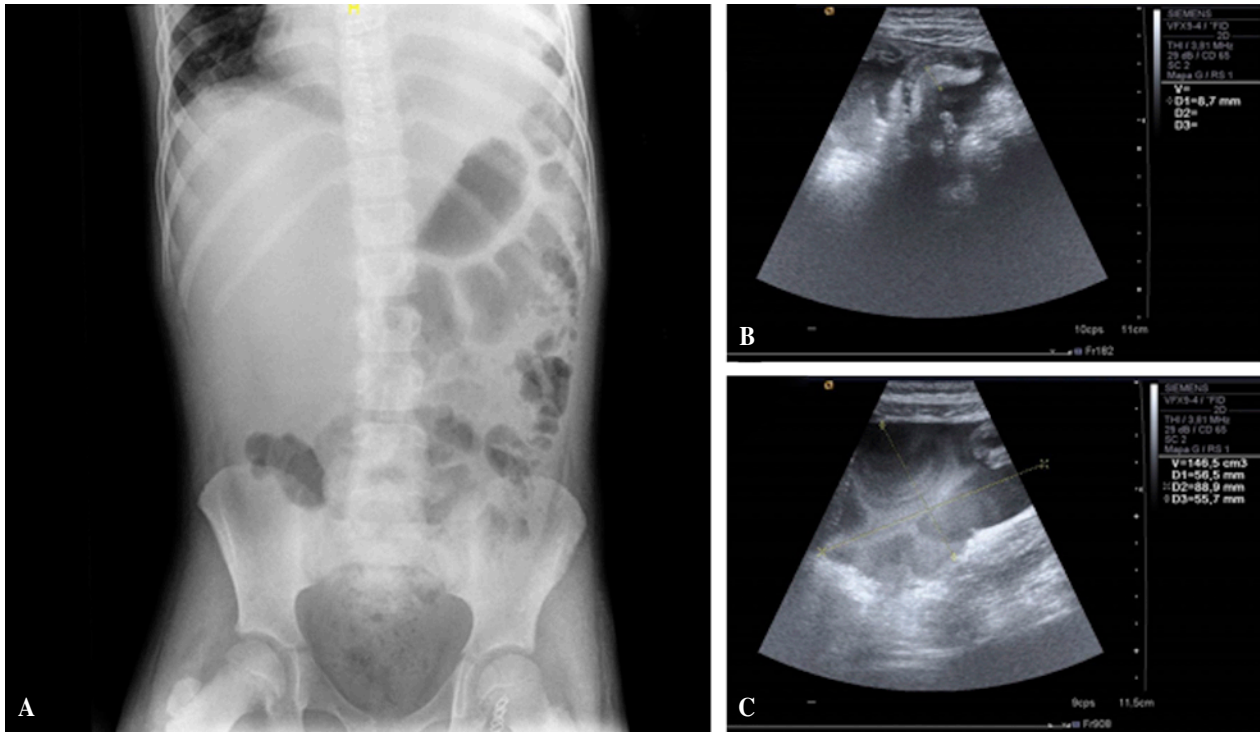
A) Abdominal X-ray: Increased density at the right hemiabdomen, with contralateral displacement of the bowel gas pattern. B) Ultrasonography: Fluctuating free fluid at the right paracolic gutter/peritoneal recess, underlying to the abdominal wall hematoma. C) Small bowel loop with a thickened, echogenic, 8.7mm transverse diameter wall.
